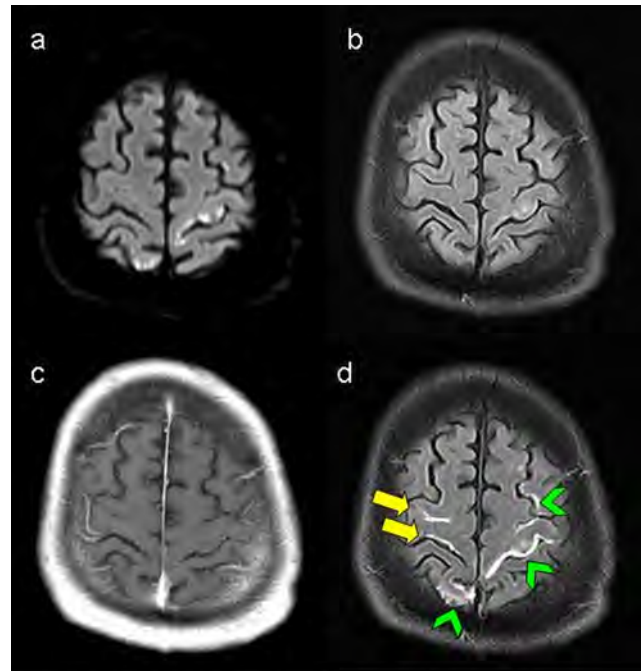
MRI of a 84 year old man with left MCA and right ACA ischemia (a: DWI, b: FLAIR) due to 90% left ICA stenosis, right ACA is supplied from left. While there is no BBB dysfunction detectable on post-contrast T1w (c), post-contrast FLAIR (d) reveals leakage of contrast agent and sulcal hyperintensity and increased parenchymal hyperintensity in acute ischemia (green arrowheads) and in remote areas (yellow arrows).
